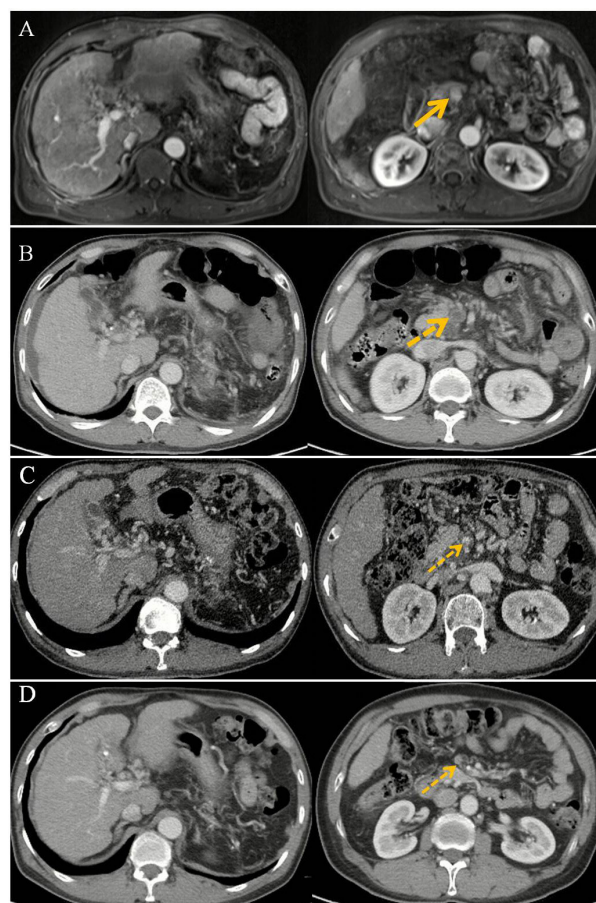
Coronal views. (A) contrast-enhanced magnetic resonance imaging performed on May 29, 2017 showing patent mesenteric vein (solid arrow); (B) computed tomography angiography performed on June 13, 2017 showing complete thrombosis in the mesenteric vein (dotted arrow).
